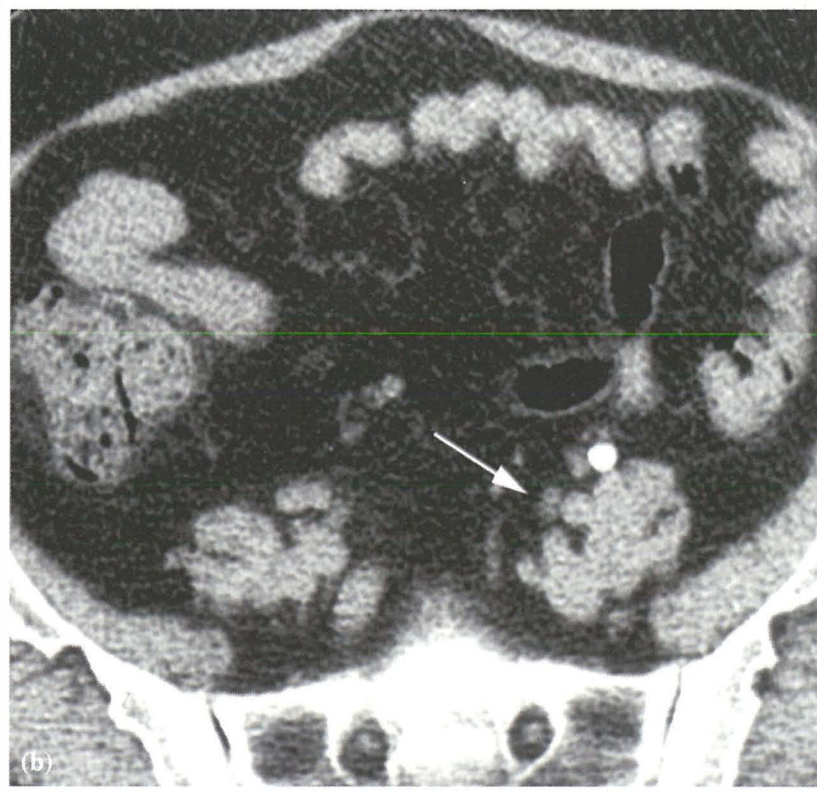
(a) Axial CT scan shows a rim of soft tissue surrounding a stone in the midportion of the left ureter (arrow). (b) On an axial CT scan of a different patient, no soft tissue is present around a gonadal vein phlebolith. The normal left ureter was followed from above and identified as separate from the calcification (arrow).
